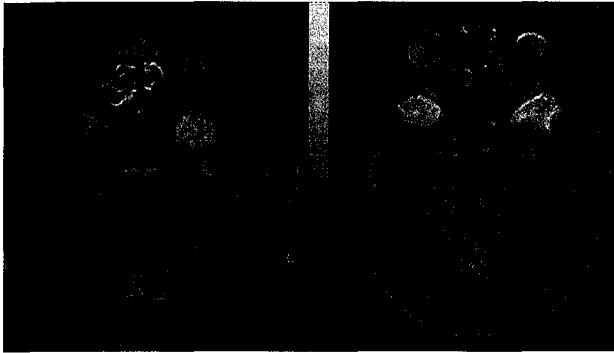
T2-weighted MRI images of the patient and the lesion site involving bilateral anterior temporal lobes.
